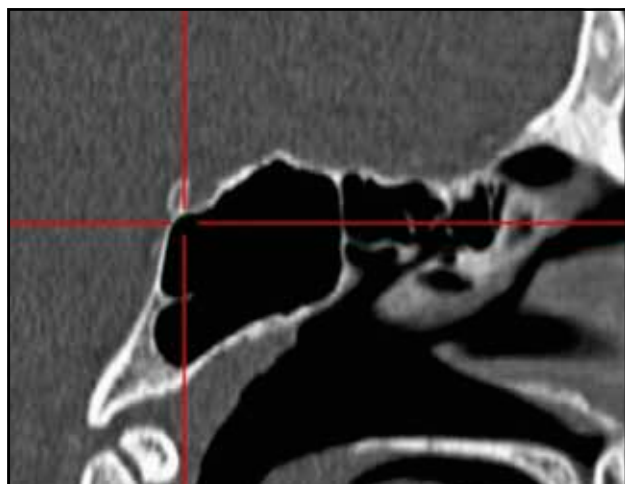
Occipital extension – inferior to the level of the vidian nerve (cranio-facial CT scan, sagittal slice).
